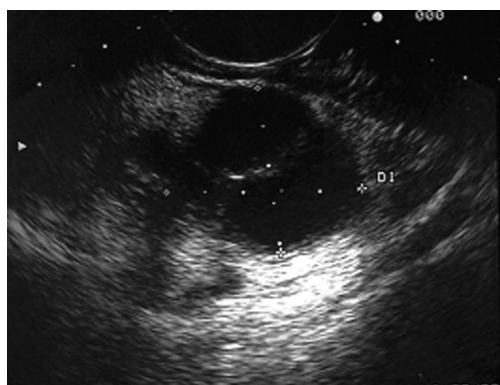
Endoscopic ultrasound image demonstrating a cystadenocarcinoma.
